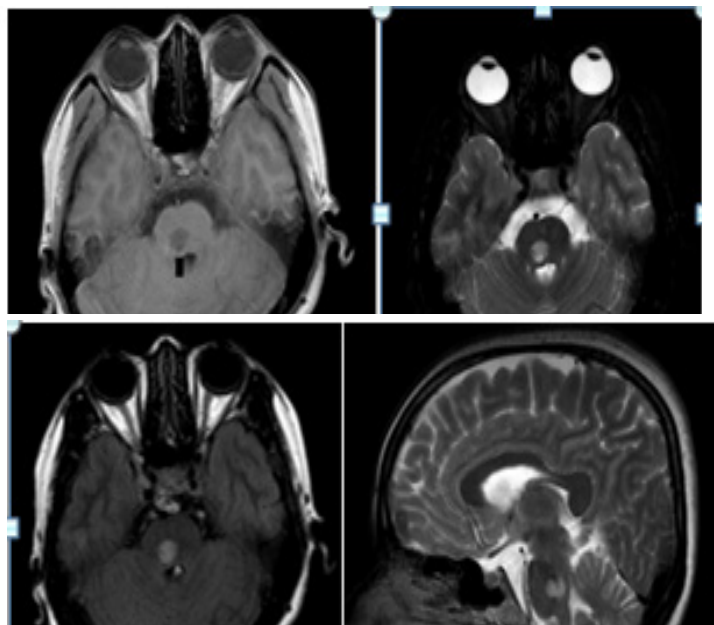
A) The patchy T1 WI image of the pons can be seen with a slightly low signal shadow; B) The patchy T2WI image of the pons can be seen with a slightly high signal shadow; C) The patchy FLAIR image of the pons can be seen with a slightly high signal shadow; D) There is a patchy T2WI image with slightly high signal shadow in the pontine axial position.
